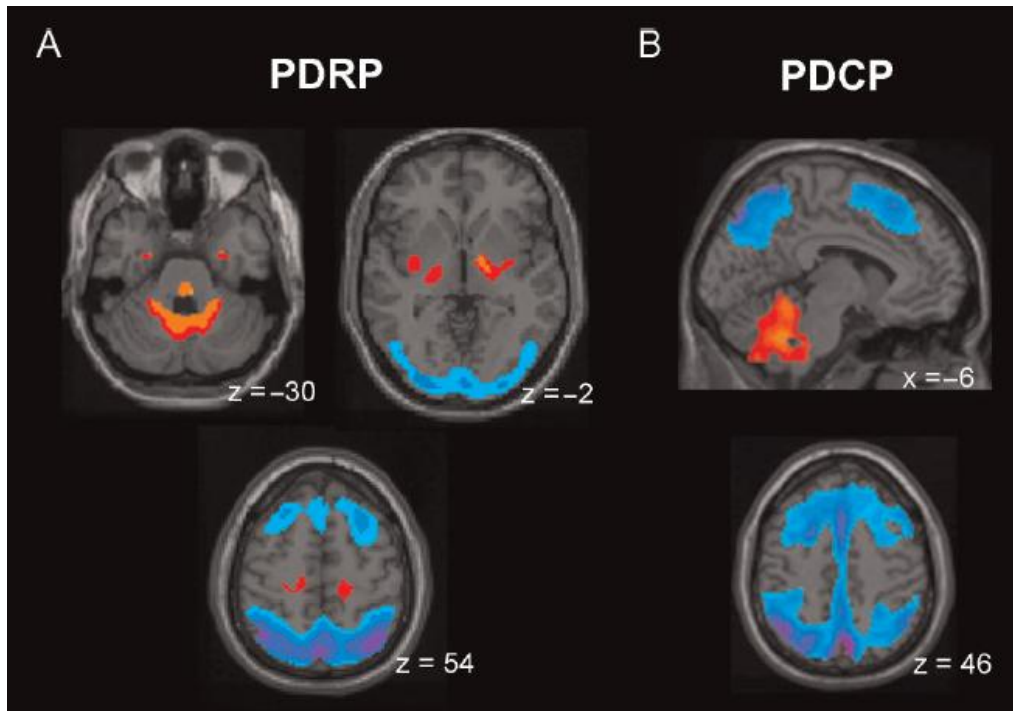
(A) Parkinson's Disease motor-related metabolic pattern. (B) Parkinson's Disease-Related Cognitive Pattern (PDCP). These patterns were identified in the network analysis of FDG PET scans.
